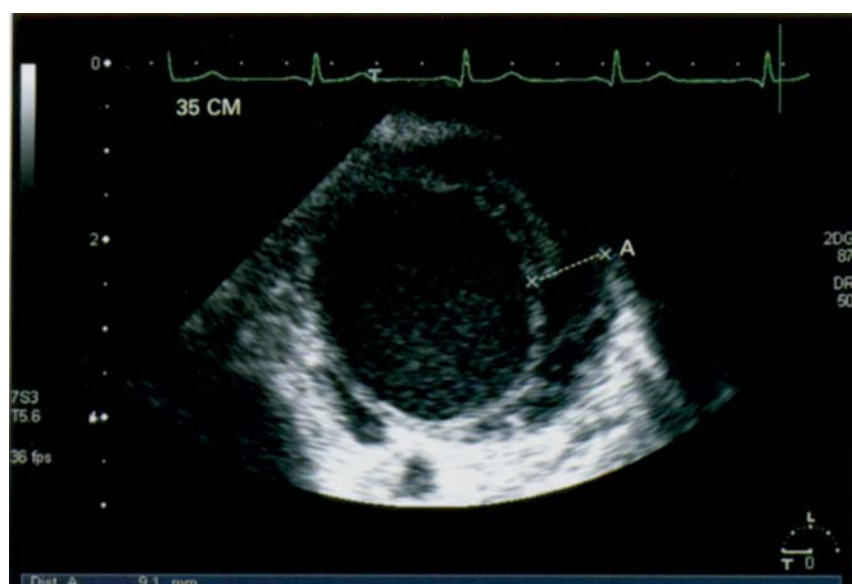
Transoesophageal echocardiographic cross sectional image of an intramural haematoma/haemorrhage of the aorta (class 2 aortic dissection), identified by the wall thickening and echo lucent areas within this part of the aortic wall, which is otherwise normal in size and structure.
